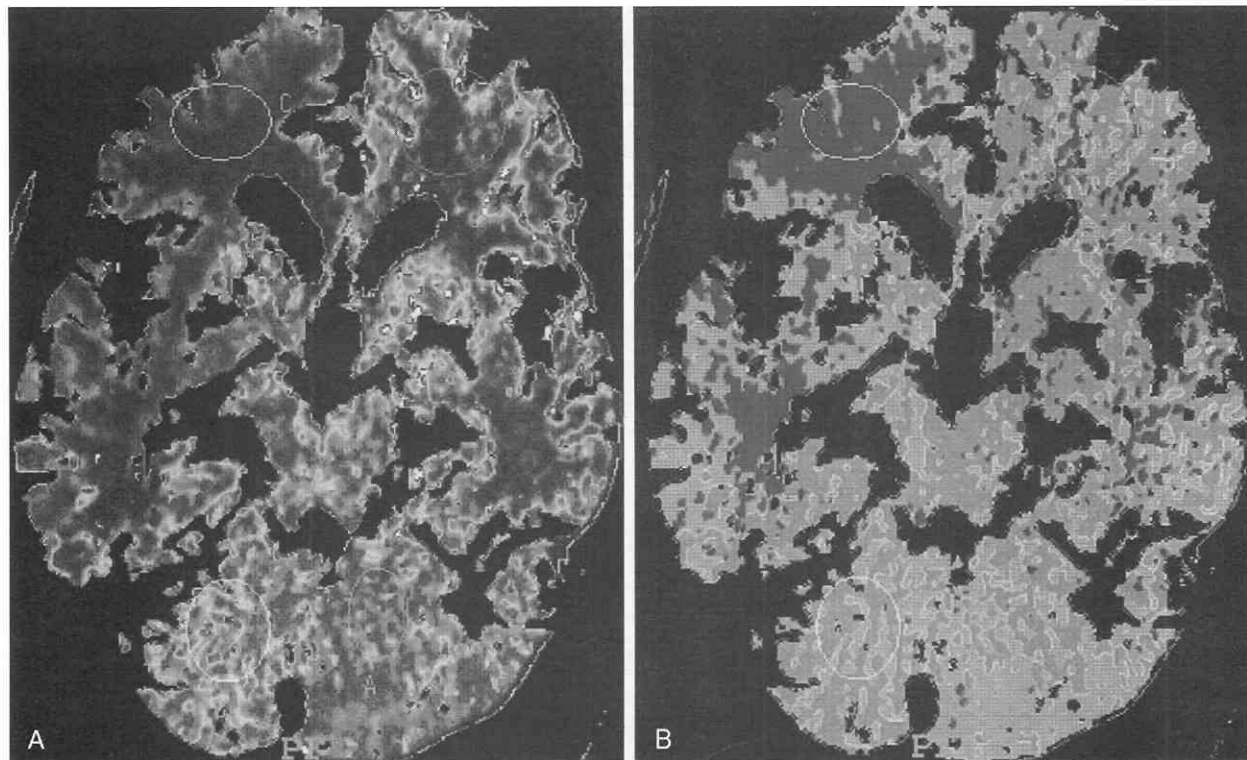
Brain perfusion study in a 64-year-old woman who presented with acute left hemiplegia caused by acute right internal carotid occlusion. The unenhanced CT was normal. Perfusion study was performed with 4×5 -mm dynamic axial scans every 2 seconds through a single brain location. Density curves that are proportional to contrast concentration were generated from brain parenchyma, an arterial input vessel, and dural sinus. These curves were used to generate the cerebral blood flow (CBF) (A) and time-to-peak (TTP) (B) maps, demonstrating decreased cerebral blood flow (blue) and increased time to peak (red) within the right cerebral hemisphere.
